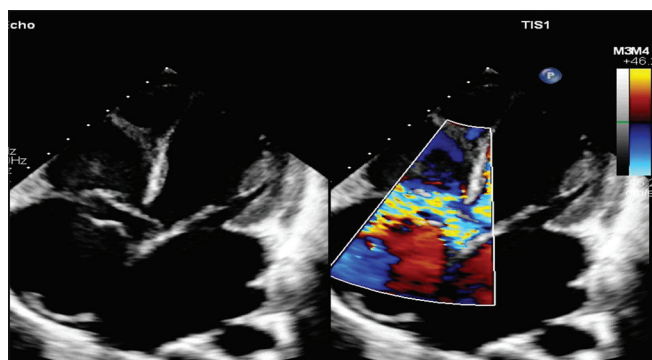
Modified apical-five chamber echocardiographic image showing sinus of Valsalva aneurysm (arrow) with rupture into right atrium just above the tricuspid valve.
